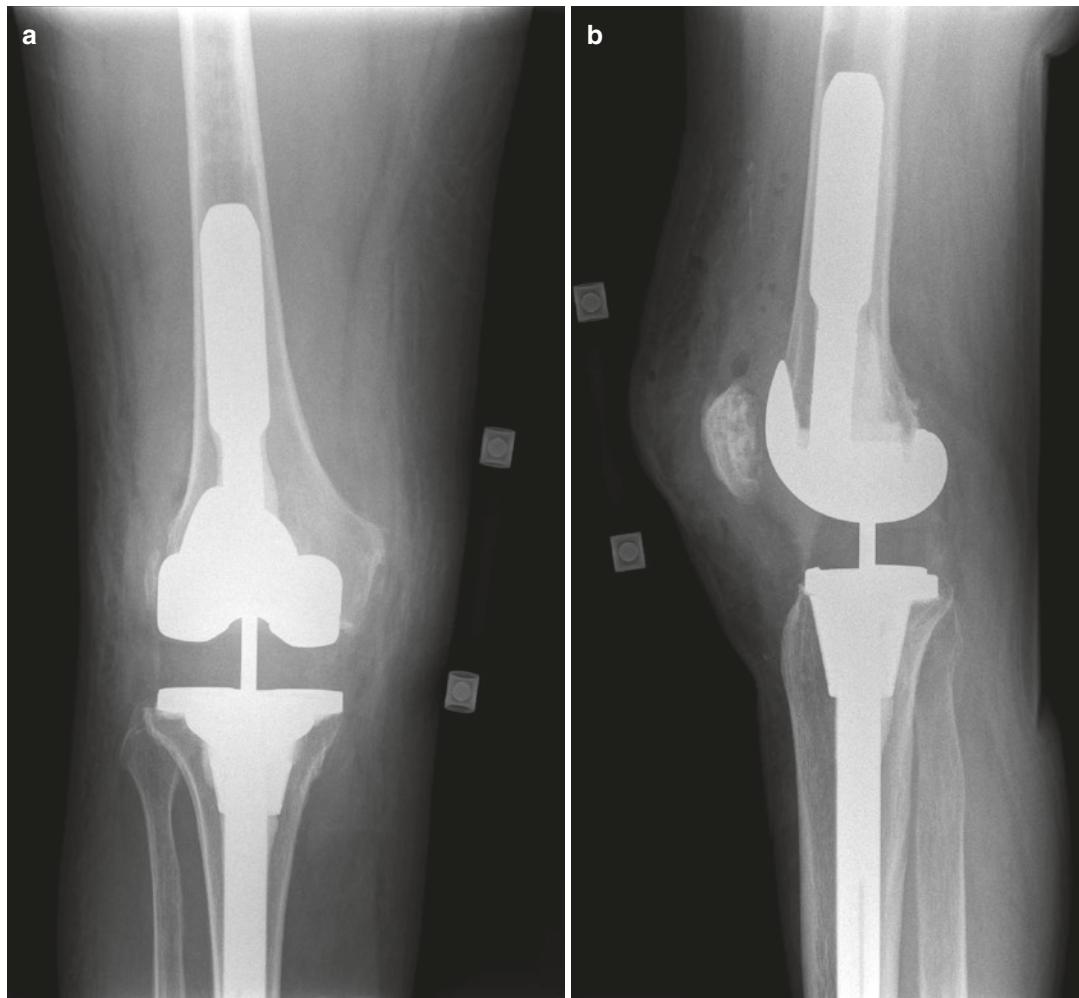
Anteroposterior (AP) (a) and lateral (b) radiographs at 2-year follow-up demonstrating well-fixed, well-aligned implants without evidence of loosening or wear
